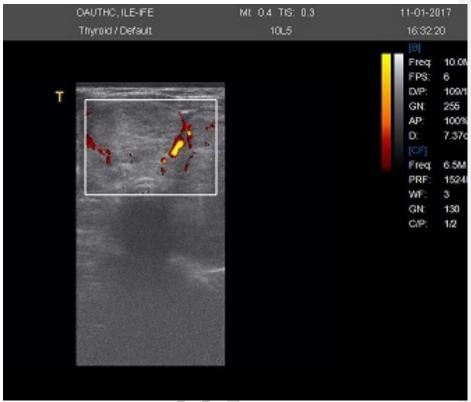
Transverse plane B mode and colour Doppler USS showing a smoothly marginated, wider than tall, isoechoic, predominantly solid nodule with perinodular vascularity.
